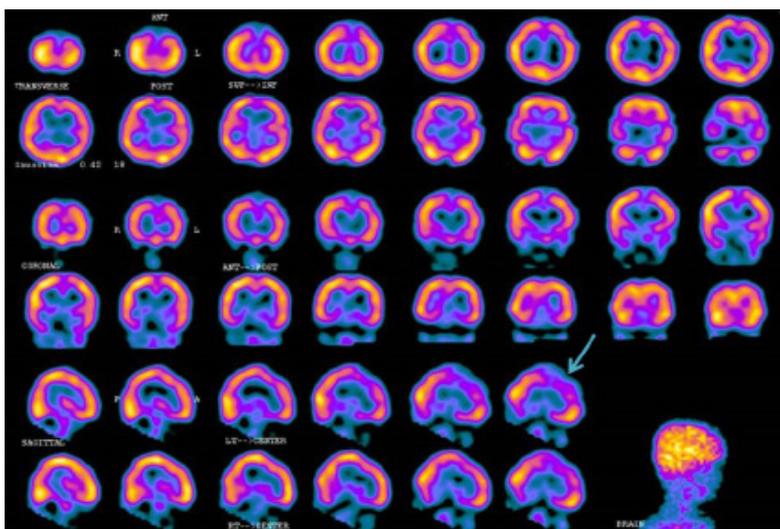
A 5 years old boy is with development delayed. Patient had autism and seizure disorder. SPECT: Decreased regional cerebral blood flow in left fronto-parietal region.
